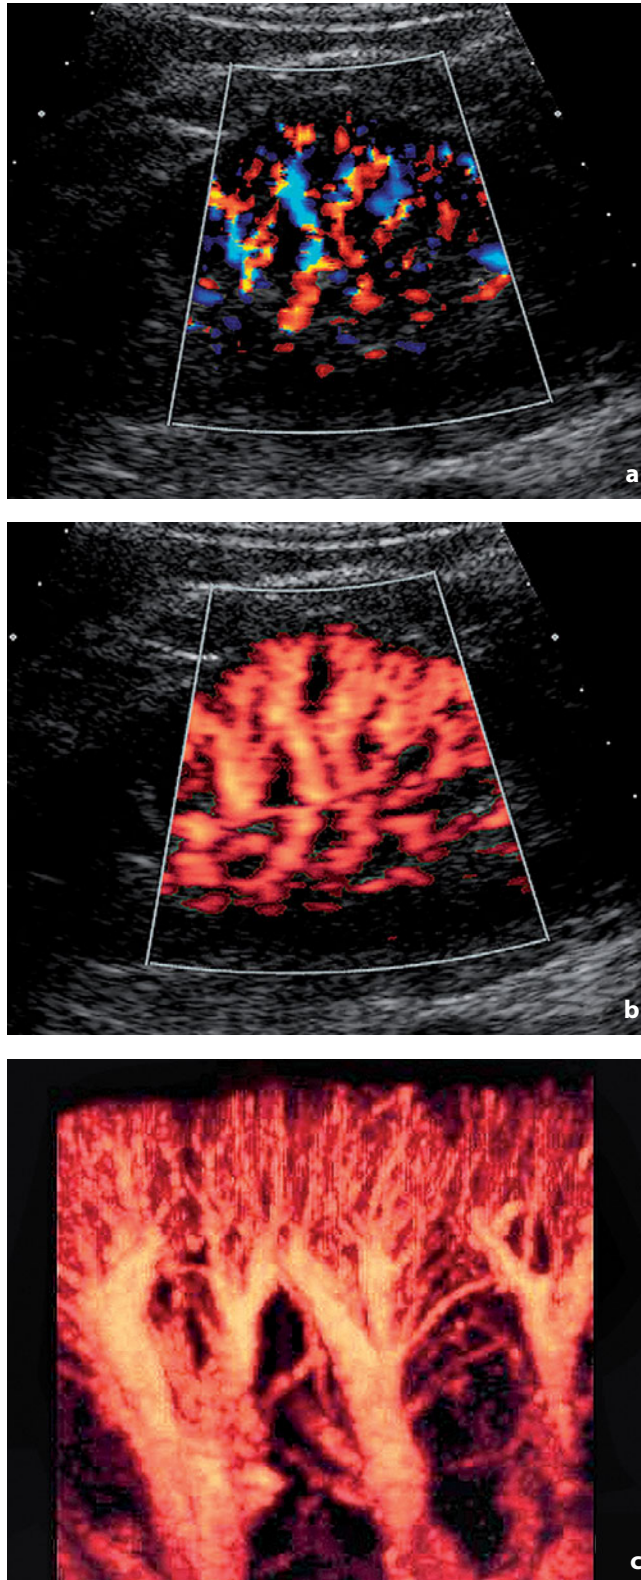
Color Doppler and power Doppler. Kidney. a Color Doppler and b power Doppler images show the intrarenal vascular flow. c Power Doppler can also provide a three-dimensional view of the parenchymal vasculature
